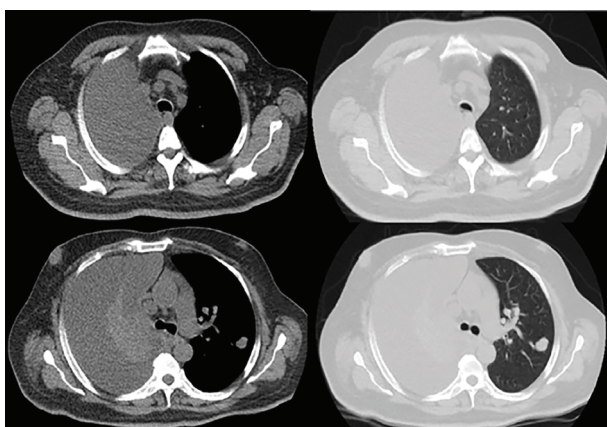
A computed tomography scan: mediastinal pleural thickening in the right hemithorax, circumferential involvement of the pleura in the right hemithorax, pleural effusion and multiple bilateral metastatic nodules
